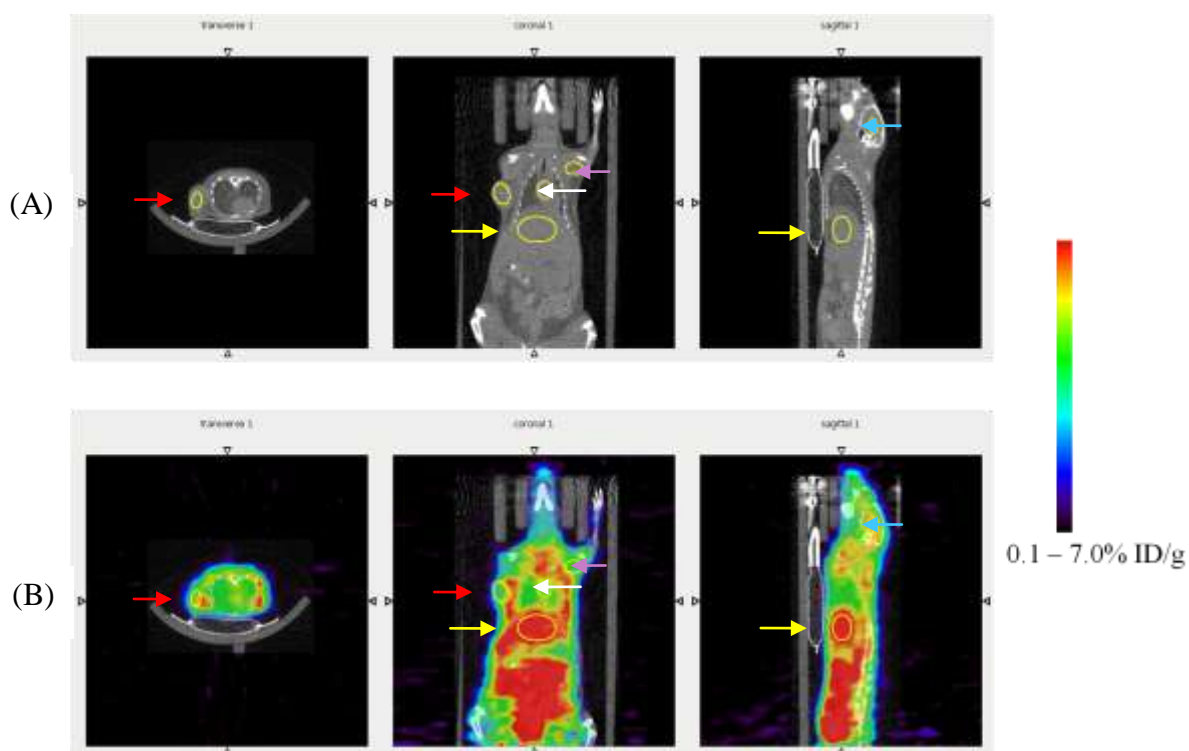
Dynamic PET image 63-65 minute pi: ROIs for tumour (transverse and coronal view, red arrow), heart (coronal view, white arrow), liver (coronal and sagittal views, yellow arrow) and muscle (coronal view, purple arrow). (A) CT image (B) PET/CT image. PET colour indicating 0.1-7.0% ID/g
